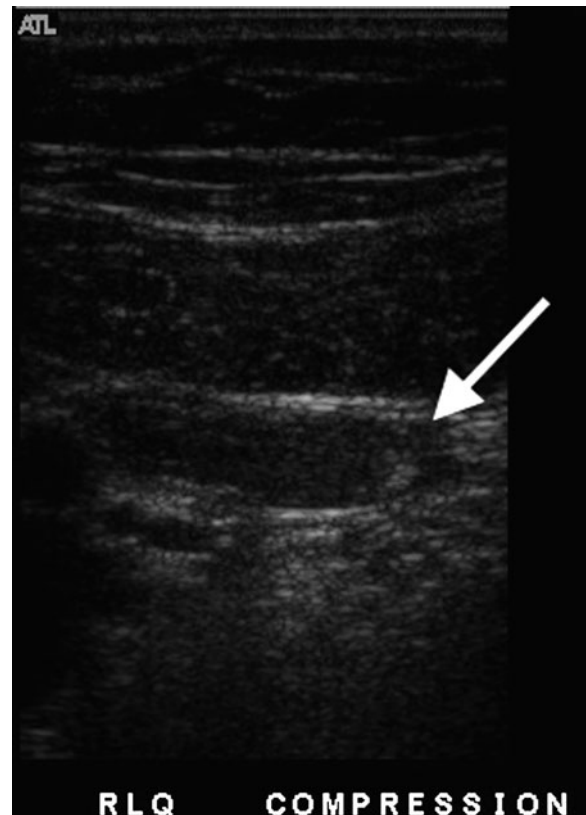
Ultrasound of 8-week patient with right lower quadrant pain, rule out acute appendicitis. Longitudinal image of a dilated appendix in the right lower quadrant with an appendicolith (white arrow)
